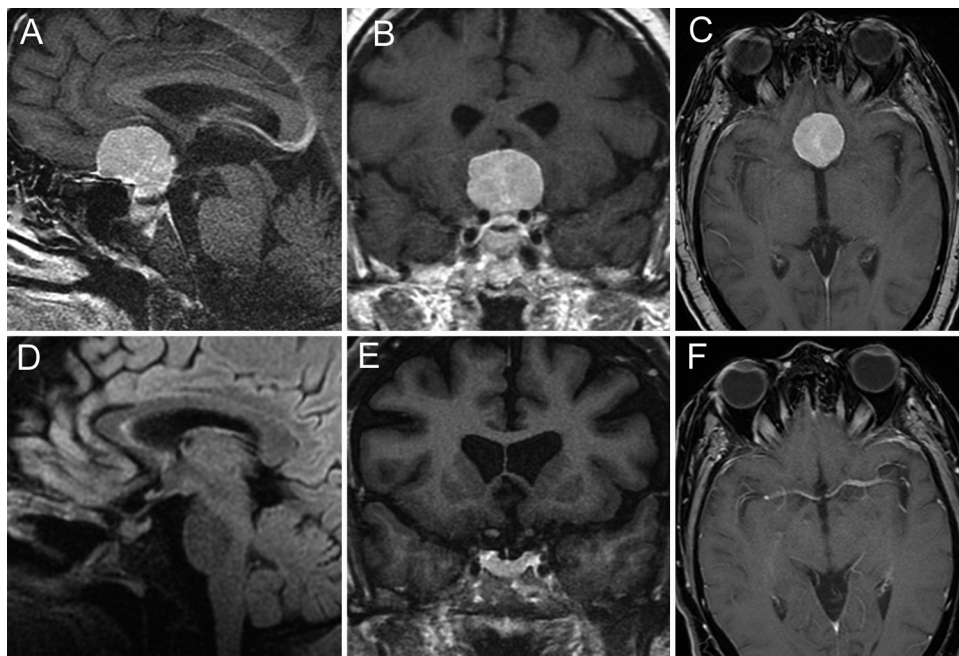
Case 1. A–C: Preoperative T1-weighted post-Gd sagittal (A), coronal (B), and axial (C) MR images demonstrating a tuberculum sellae meningioma with optic compression. Complete Simpson Grade I removal including underlying hyperostotic bone was achieved using the endoscopic endonasal extended transsphenoidal approach. D–F: Postoperative sagittal (D), coronal (E), and axial (F) MR images showing gross-total resection of the tumor with decompression of the optic nerves and preservation of the pituitary stalk and gland.
